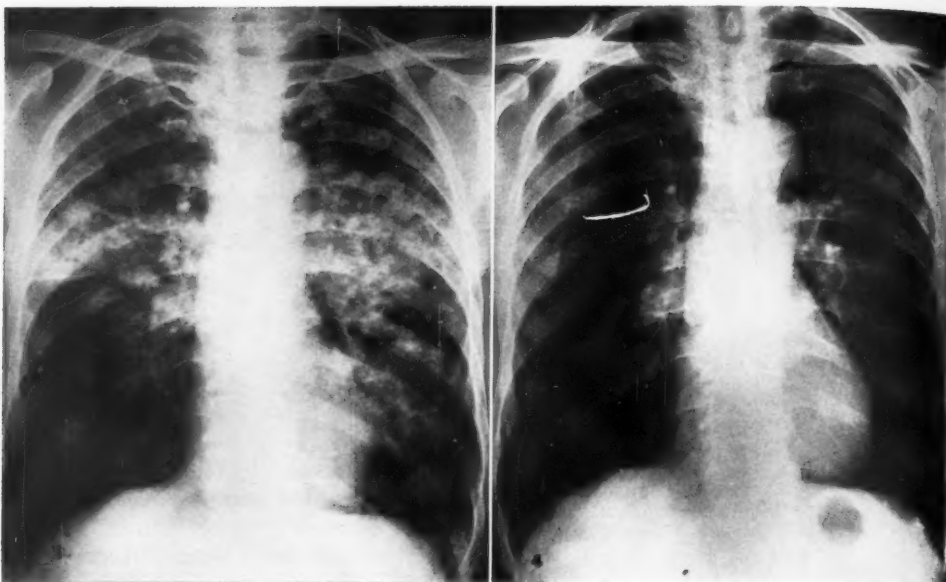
Case II. Roentgenogram one day after exposure to silage fumes. Patchy infiltration in both lungs with confluence in the midportions.
